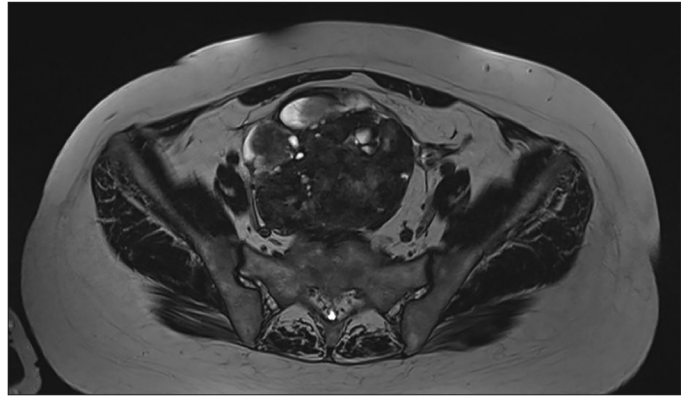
MRI scan of the tumor (axial)
